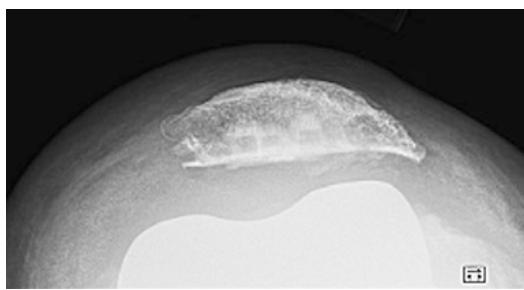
Merchant preoperative radiograph showing a well-fixed patellar component
